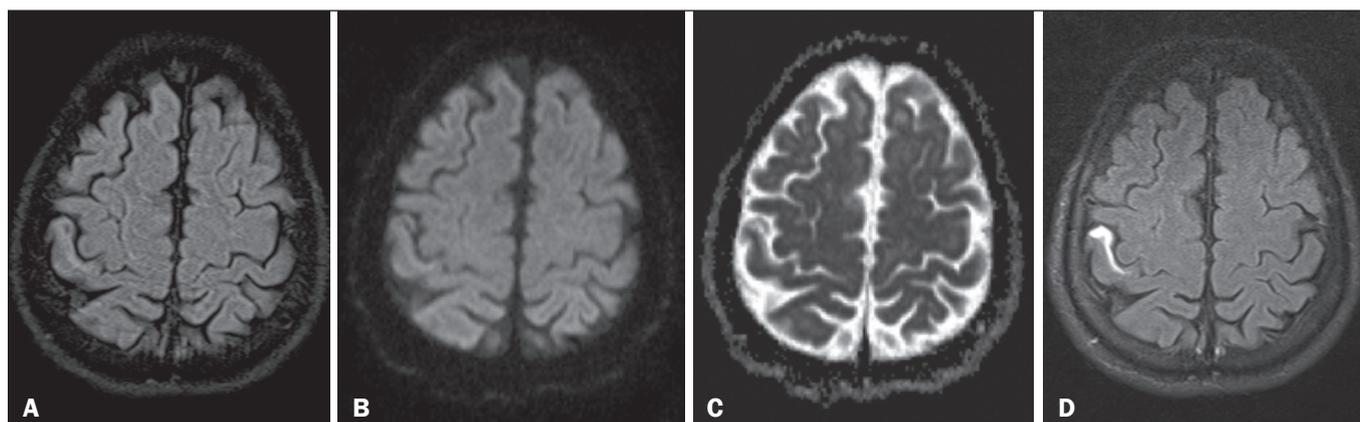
A: Axial FLAIR image. Note the subtly hyperintense signal in the anterior cortex of the postcentral gyrus. B,C: Corresponding axial DWI (B) and ADC map (C). There is a barely discernible hyperintense signal on DWI, although there is no evidence of low signal intensity on the ADC map (i.e., there is no restricted diffusion in the region). D: Gadolinium-enhanced FLAIR image showing marked contrast uptake in the affected area of the postcentral gyrus.
